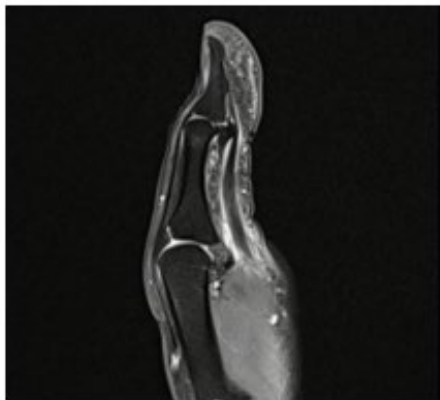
Preoperative magnetic resonance imaging of the left thumb showing an accessory sesamoid bone at the IP joint palmar plate of the thumb.
